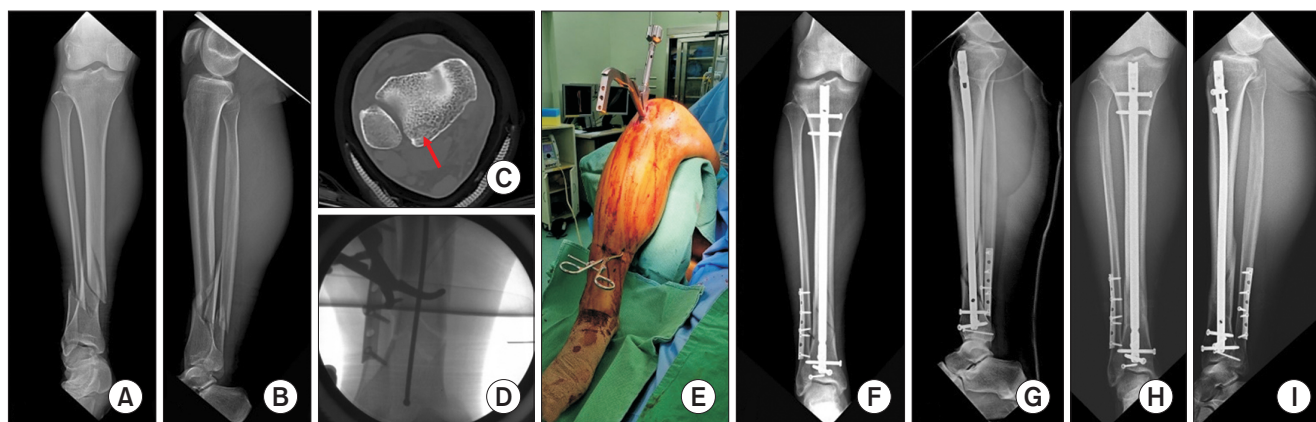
(A, B) A 31-year-old man had a sports-related injury resulting in a distal tibiofibular fracture classified as AO 42-B2. (C) Computed tomography imaging revealed a posterolateral distal tibia intra-articular fracture (red arrow). (D, E) The fibular fracture was addressed with open reduction and internal fixation using a plate, and percutaneous reduction of the distal tibia oblique fracture was performed using pointed reduction forceps facilitated by an infrapatellar approach and guide pin insertion. (F, G) The intra-articular fracture was subjected to lag screw fixation, and postoperative radiography confirmed the restoration of normal alignment. (H, I) At 4 months postoperative, bone union was achieved without any significant radiological or clinical complications.
